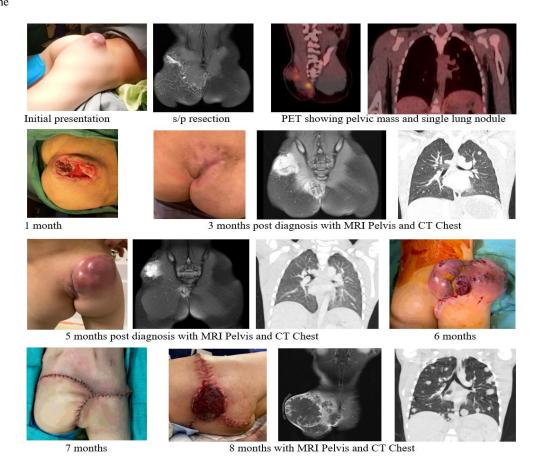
Timeline of clinical and radiographic.
